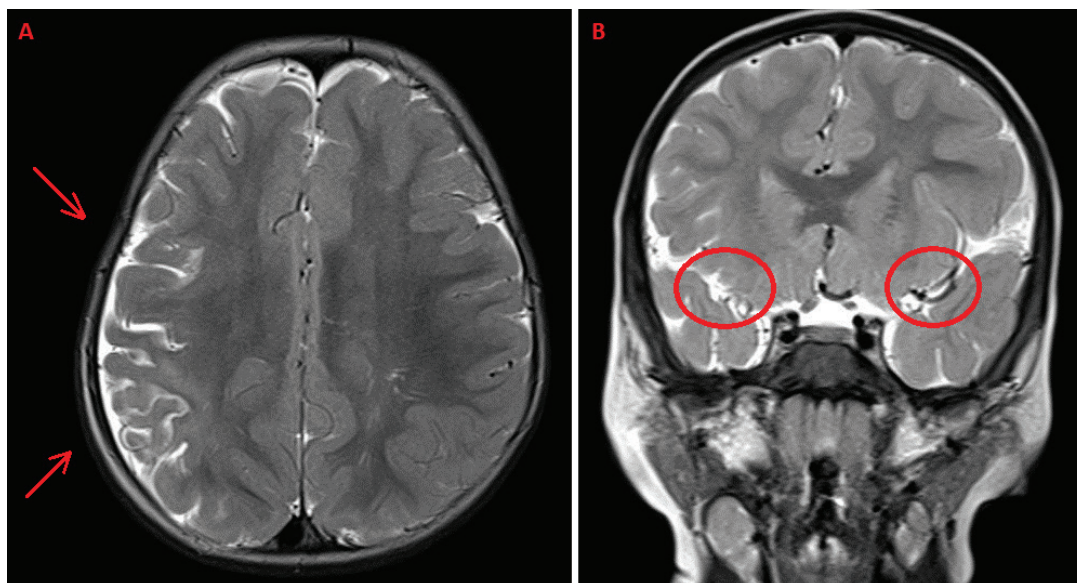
Cranial imaging of case 11. (A) Cortical atrophy and prominent sulcus of right frontoparietal region in axial T2-weighted magnetic resonance imaging (MRI). (B) Thinning in the right middle cerebral artery branches were observed in coronal T2-weighted MRI.
